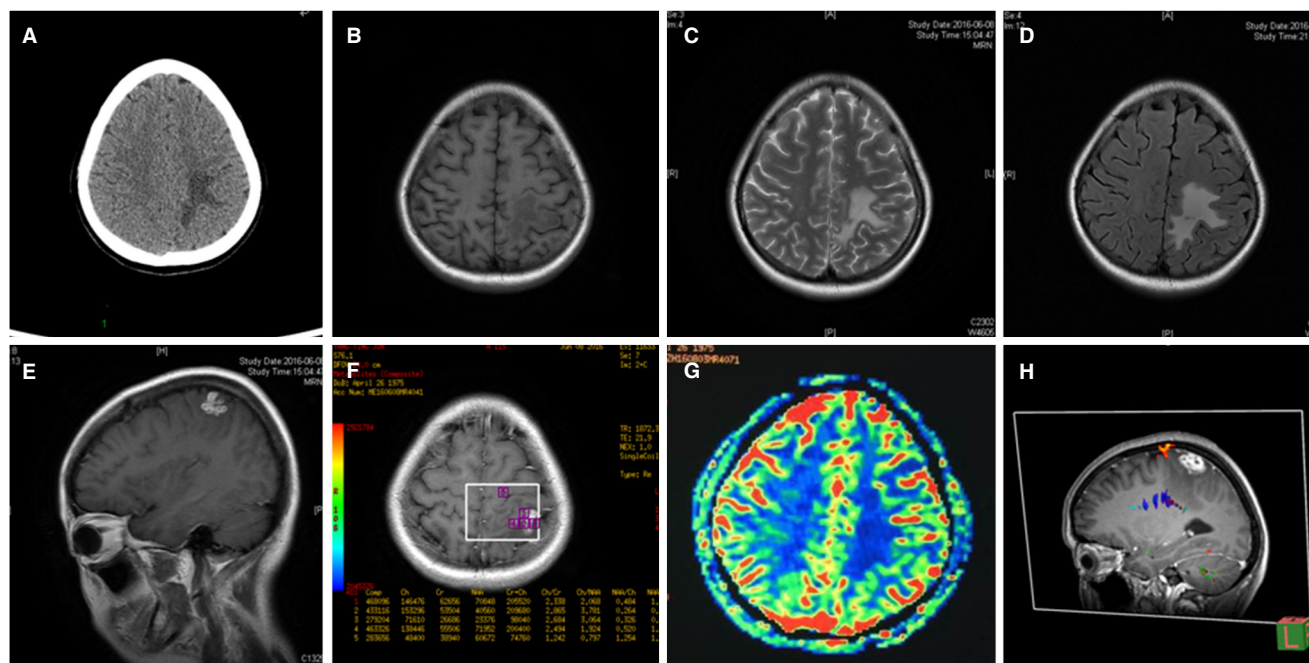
Preoperative radiological features of cerebral sparganosis. A: axial view of CT scanning showed irregular edema of the left parietal lobe; B: axial view of T1WI MRI showed a slight edema of the left parietal lobe; C: axial view of T2WI MRI; D: axial view of FLAIR MRI; E: sagittal view of enhanced T1WI MRI showing an irregular enhanced lesion of the left parietal lobe; F: axial view of enhanced T1WI MRI; G: axial view of MR perfusion showed the lesion was hypometabolic; H: sagittal view of preoperative DTI. CT: computed tomography; MRI: magnetic resonance imaging; NAA: *N*-acetyl-aspartate; T1WI: T1 weighted imaging; DTI: diffusion tensor imaging
